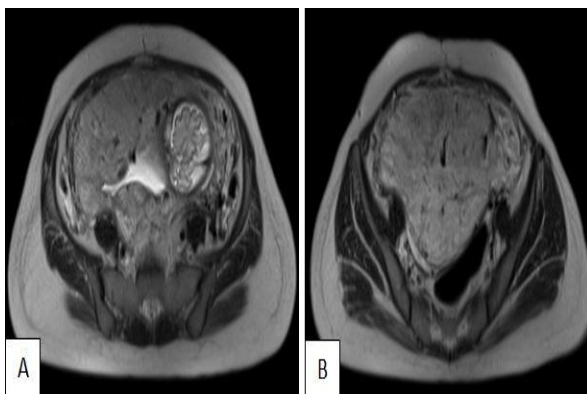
MRI Pelvis axial T2WI sequence (A,B) showing placenta previa
